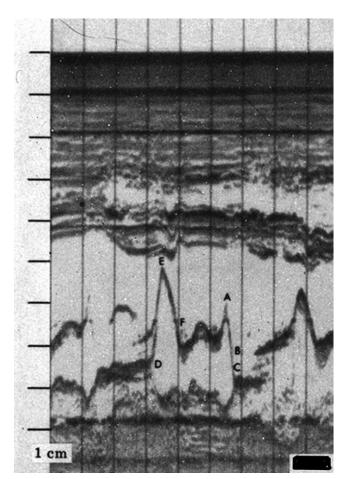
Normal M-mode recording of the mitral valve. (From Feigenbaum H. Echocardiography. 1st ed. Philadelphia, PA: Lea and Febiger; 1972.)
